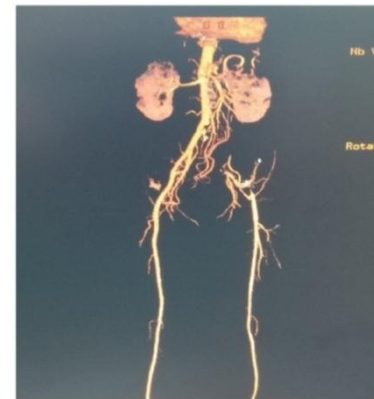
Preoperative CTA image
